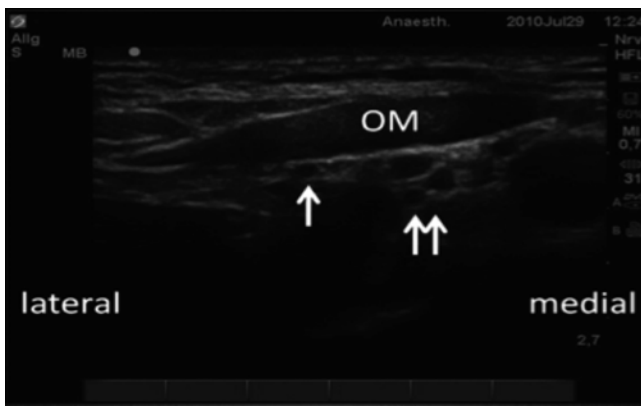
Ultrasound image of supraclavicular anterior approach to the suprascapular nerve. *Single arrow* = suprascapular nerve, *double arrow* = brachial plexus; *OM* omohyoid muscle (Image courtesy of Dr. Róbert Rapčan, Bardejov, Slovakia)
